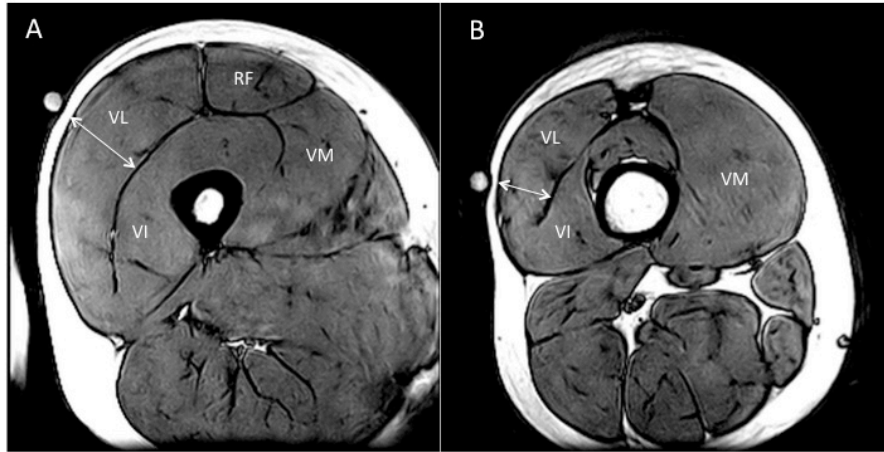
Transverse section of mid thigh taken by MRI. Arrows indicate VL thickness at the point of testing at A) proximal motor point, and B) distal motor point.
